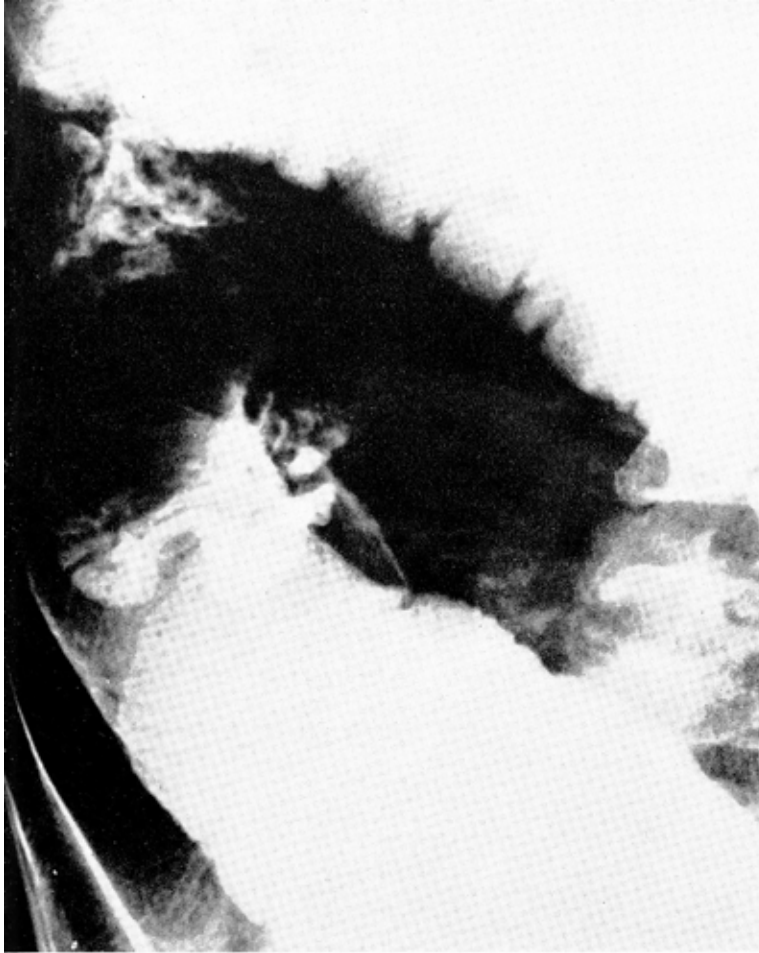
Poor reproduction of roentgenogram with dilatation of the terminal ileum at point of apparent obstruction.
